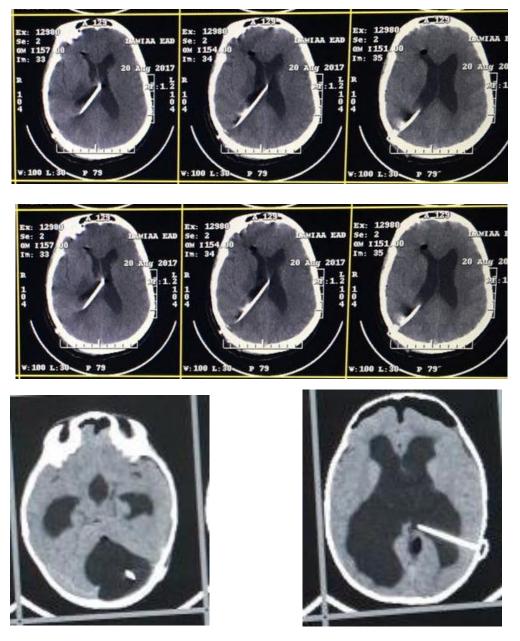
MRI show: Y connected VP + CP Shunt
